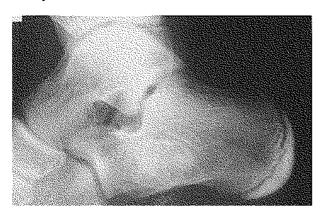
Postoperative xray view after six months with cancellous bone graft in place.
